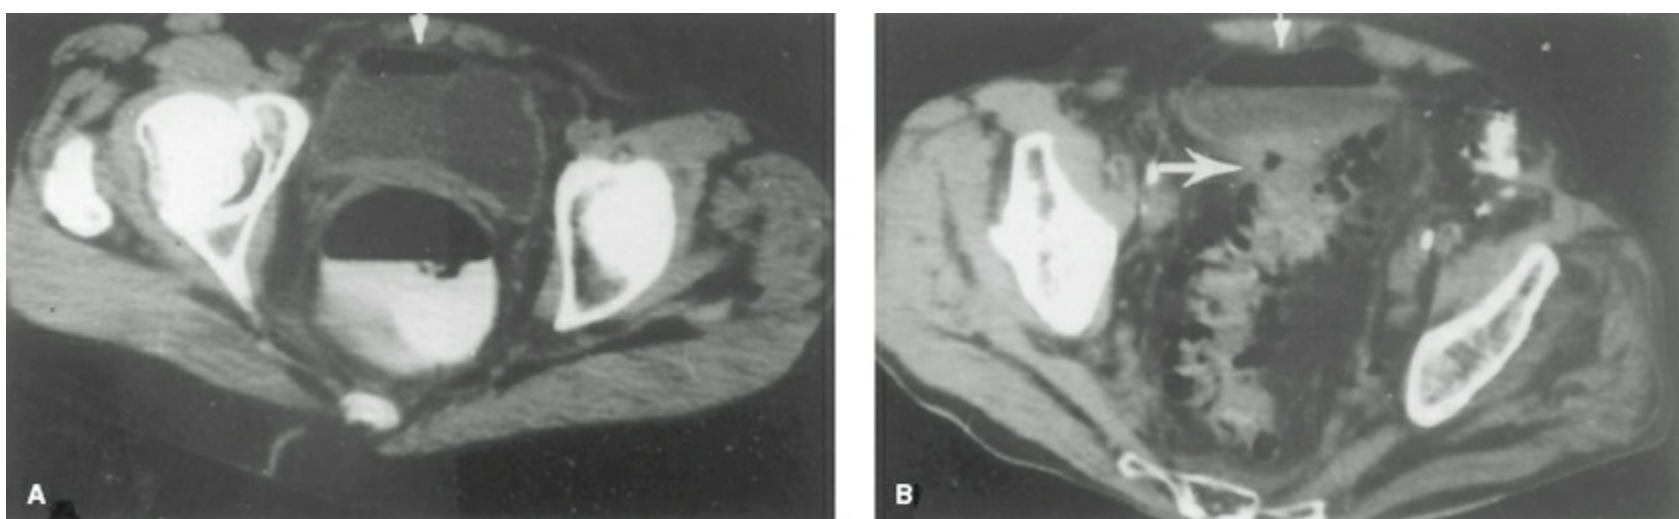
A: Computed tomography scan demonstrating air in the urinary bladder (arrow) in the presence of a colovesical fistula secondary to diverticulitis. B: Air in the urinary bladder (small arrow) in association with a paravesical inflammatory mass (large arrow). (Reproduced with permission from Sarr MG, Fishman EK, Goldman SM. Enterovesical fistula. *Surg Gynecol Obstet*1987;164(1):41–48.)
